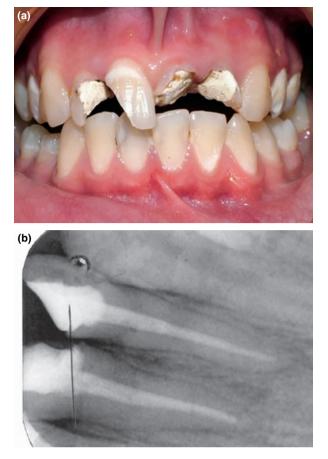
(a) The intraoral view of the patient before treatment. (b) The radiographic view of the patient before treatment.
